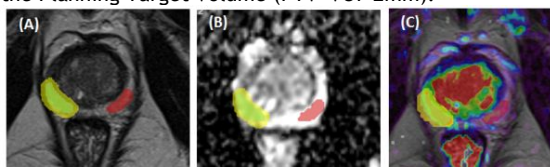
Tumor volume of interest (VOI) defined on abnormal T2-MRI (A) is highlighted in green. VOI+2mm margin is delineated in yellow and contralateral normal appearing tissue is defined in red. All these volumes are reported on ADC (B) and Ktrans (C) modalities for multi-parametric analysis.
